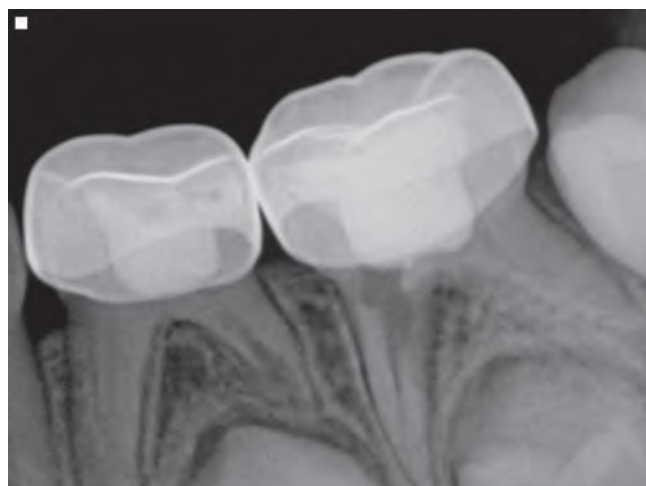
Follow-up periapical radiograph of pulpotozimized primary mandibular left molars. The mesial root of the second molar shows internal resorption. The distal root of the first molar shows atypical internal resorption that may be related to physiologic resorption process and/or pulp inflammation.
